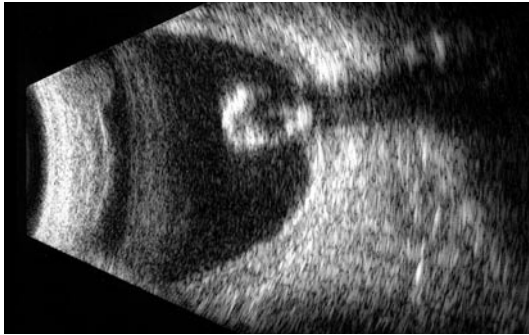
Ultrasound image of an “IOFB.” The patient had a chronic IOFB injury. The eye was aphakic but vitreous hemorrhage prevented direct inspection of the posterior pole. The mass suspected to be the IOFB on the ultrasonogram proved to be the calcified crystalline lens. The IOFB has dissolved over time and was not found during surgery
